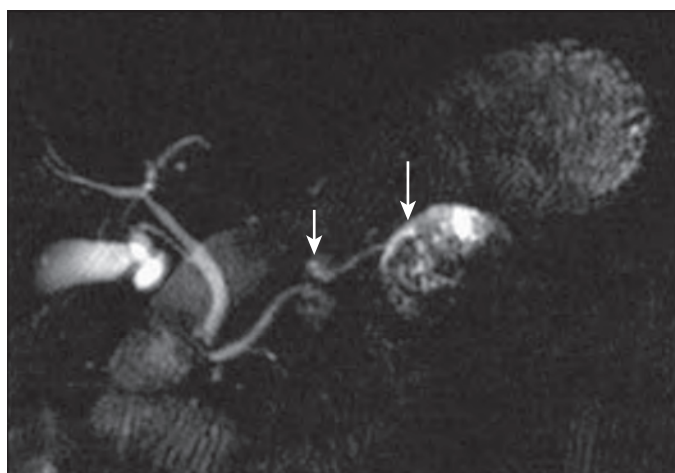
Acute pancreatitis with pancreatic duct rupture and pseudocyst. Thick-slab T2-weighted rapid acquisition and relaxation enhancement (RARE) MRCP image shows disrupted pancreatic duct (*short arrow*) and peripancreatic pseudocyst (*long arrow*) containing low signal intensity debris. (From Ly JN, Miller FH: *MR imaging of the pancreas: A practical approach*. Radiol Clin North Am 40:1289–1306, 2002.)
